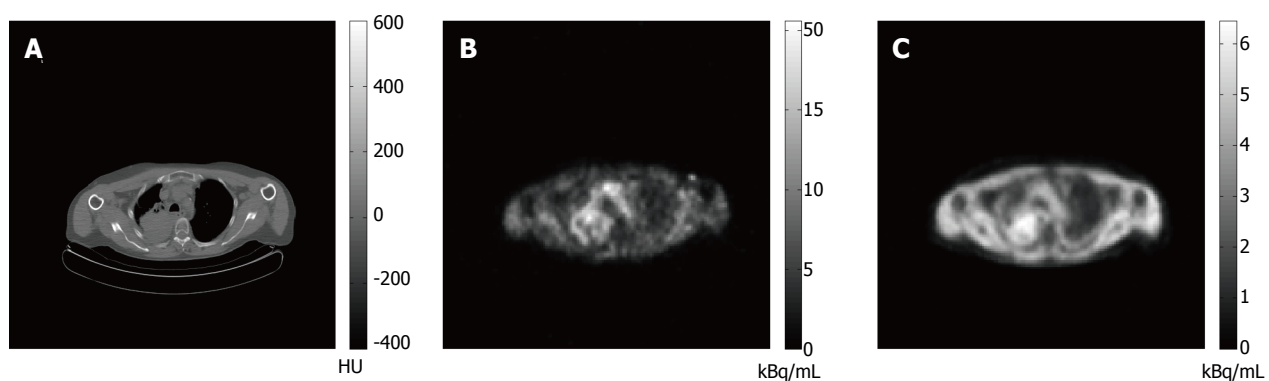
Example of consecutive perfusion and hypoxia positron emission tomography in a patient with non-small cell lung cancer. A: Low dose computed tomography; B: Perfusion image (averaged image acquired over time interval 30-120 s after injection of 370 MBq [^{15}O]H $_2$ O); C: Hypoxia image (averaged image over time interval 40-70 min after injection of 185 MBq [^{18}F]FAZA).
